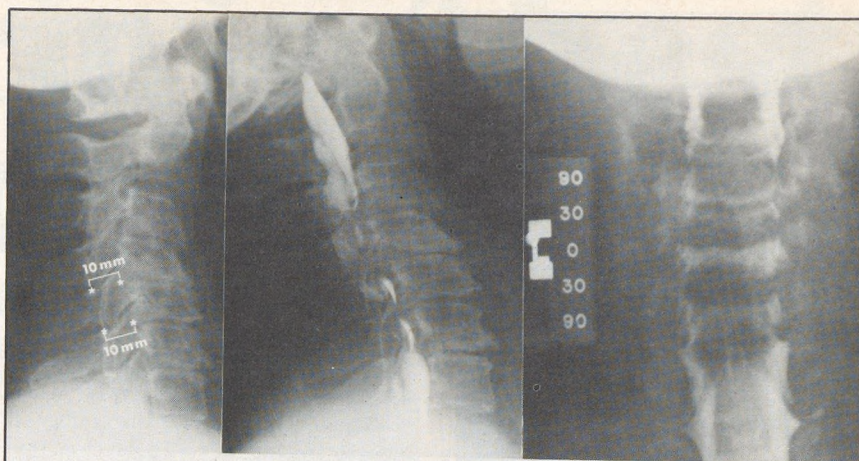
Plain x-ray and myelogram views of the cervical spine of a patient with myelopathy. The cord space is decreased to 10 mm on the plain film. On the myelogram contrast material does not flow between the cord and osseofibrous ridges.
